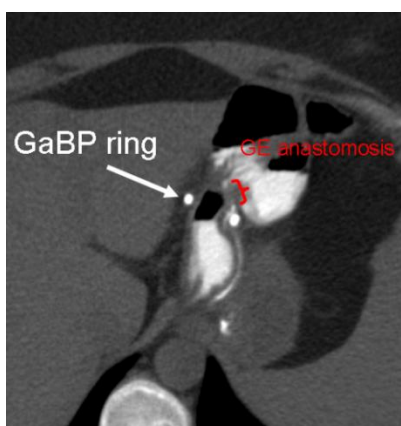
CT-Scan of abdominal cavity after LBRYGB with GE anastomosis stenosis after LBRYGB, the ring did not influence stenosis.
